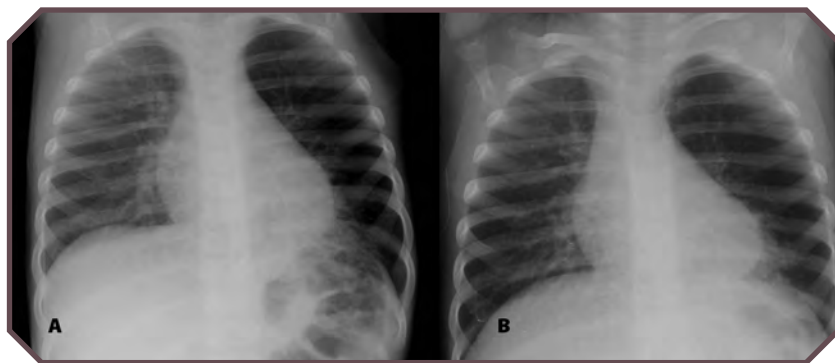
Foreign body (peanut) in the right mainstem bronchus. A. Right and B. left lateral decubitus radiographs show no change in the volume of the right lung with a change in patient position, which indicates air trapping. Conversely, the left lung changes in volume with the change in patient position, which is a normal finding that indicates no air trapping. The peanut was removed via a bronchoscope.
